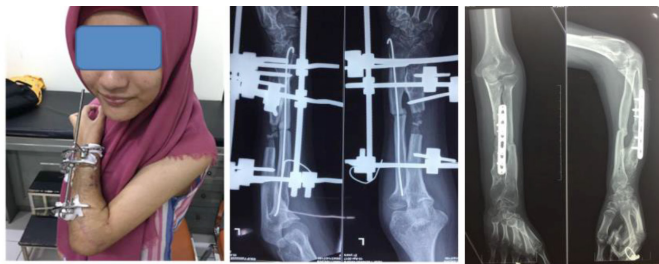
Clinical and radiographs of the left forearm in patient 3, sequences of ulnar lengthening, with osteotomy for correction of radial bowing and conversion of ilizarov frame into internal fixation
